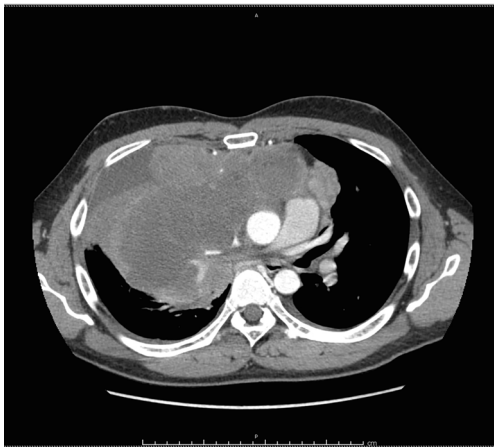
CT image of a 36-year-old male with non-Hodgkin's lymphoma adhered to the pleura and pericardium and with signs of bronchial and vascular compression. CT, computed tomography.
